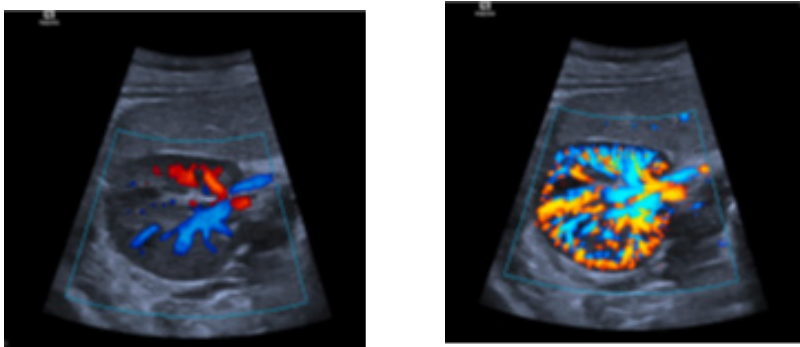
Image of the kidney using conventional colour Doppler (left) and Slow flow Doppler (right).
